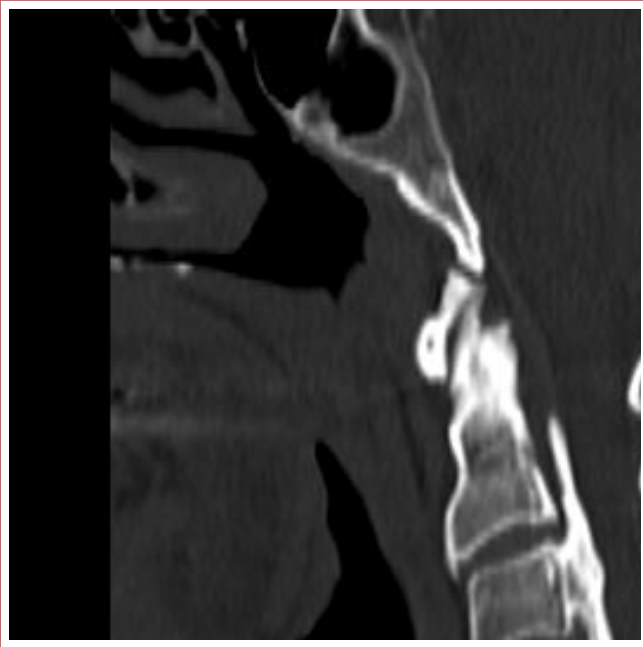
Preoperative CT sagittal image
